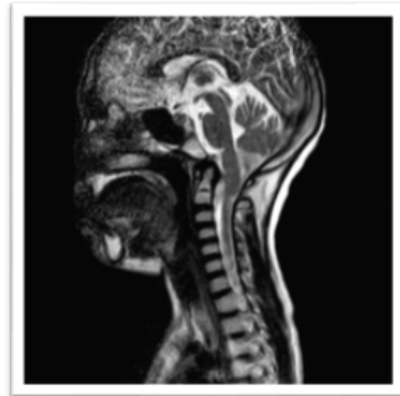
MRI CERVICAL SPINE showing short clivus with retroflex dens and overcrowding of cerebellar tonsils at foramen magnum
